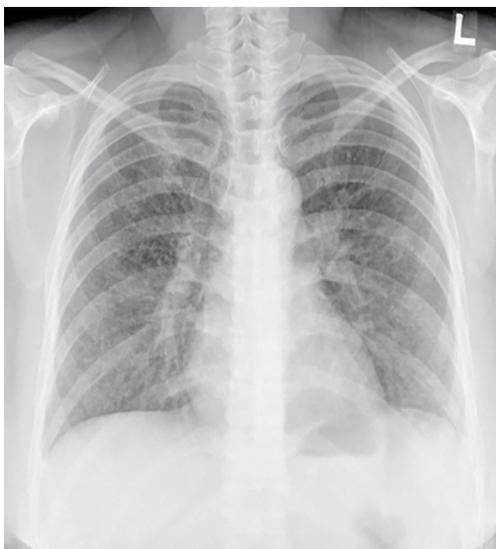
Follow-up chest radiograph showing an increased peribronchial infiltration in both the lungs compared to the initial radiograph.
